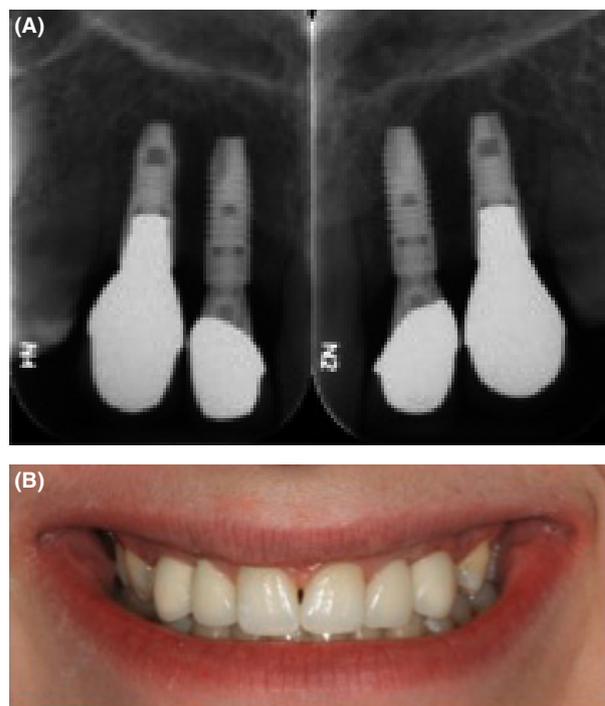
(A) Postoperative periapical radiographs were taken to assess marginal bone levels around the implants. (B) An extraoral photograph of treatment outcome.
